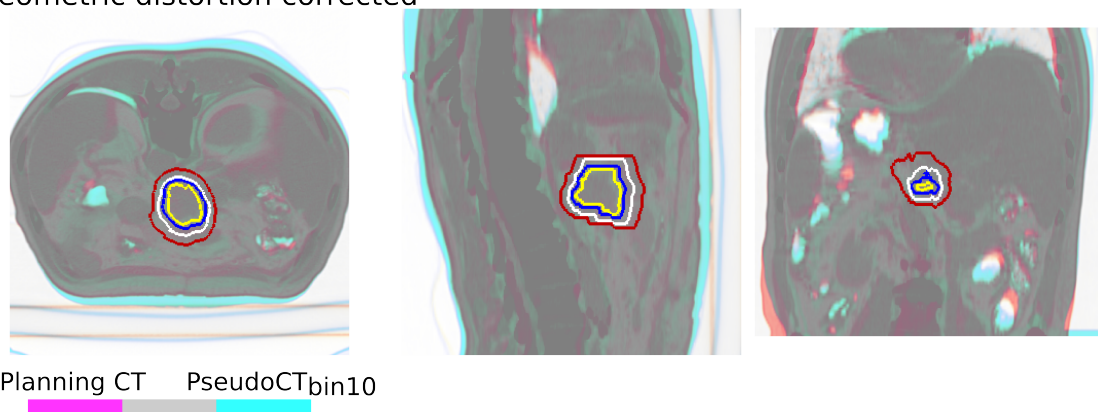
Overlay of the planning CT with the CT_{MRI-10} for patient H13 in which the differences in the patient's external surface are visible, for the case of the raw images. Using the geometric distortion correction the differences are minor.
